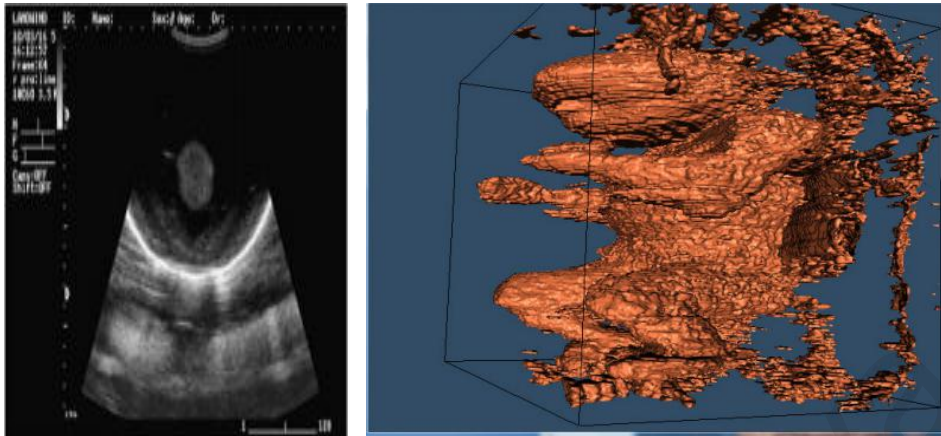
16 3D Reconstruction of Fetal Ultrasound Image use VTK. On the left, it is original image. On the right, it is the result after 3D reconstruction.
